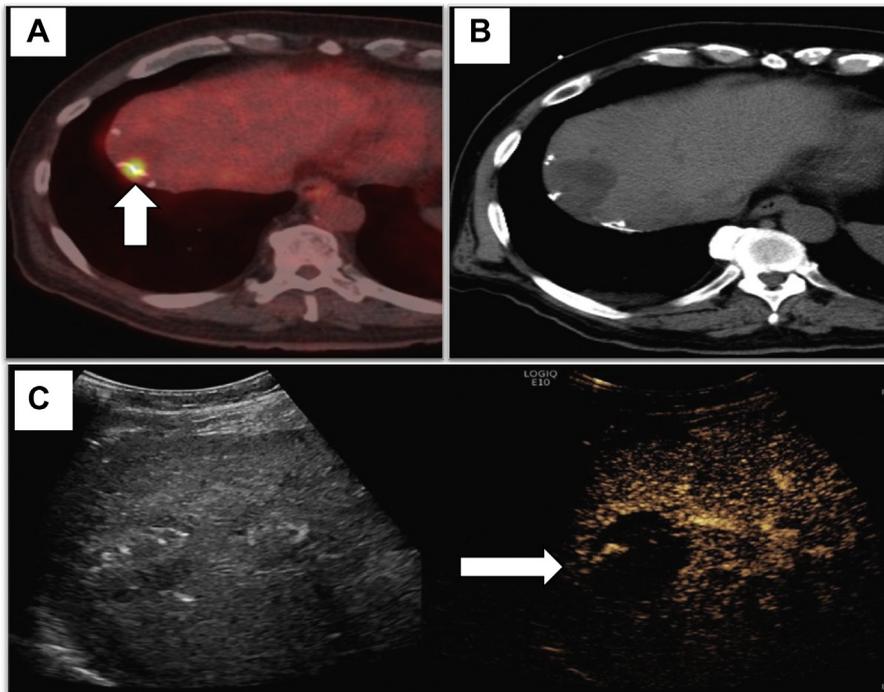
Percutaneous liver ablation in a 69-year-old man with a history of metastatic gastrointestinal stromal tumor, who now presents with recurrent tumor on PET-CT imaging in the region of prior percutaneous ablation. Recurrence is seen as FDG-avidity in the periphery of prior ablation zone (A, arrow), which is indistinguishable from necrotic tissue on noncontrast CT (B). Intravenous iodinated CT contrast was contraindicated owing to the patient's poor renal function. To ensure complete local control, US contrast was injected to localize small viable tissue (C, arrow) and to assess for complete ablation margins after completion of second ablation.
